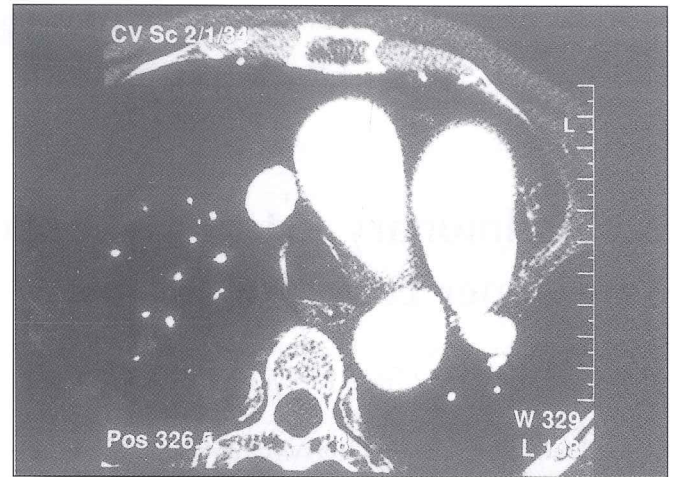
Thorax computed tomography on admission.
